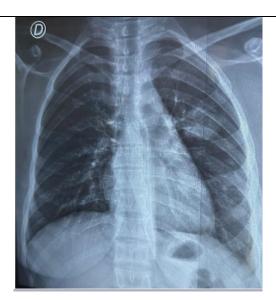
Chest X-ray revealed heterogeneous opacity in the left hilar region.
